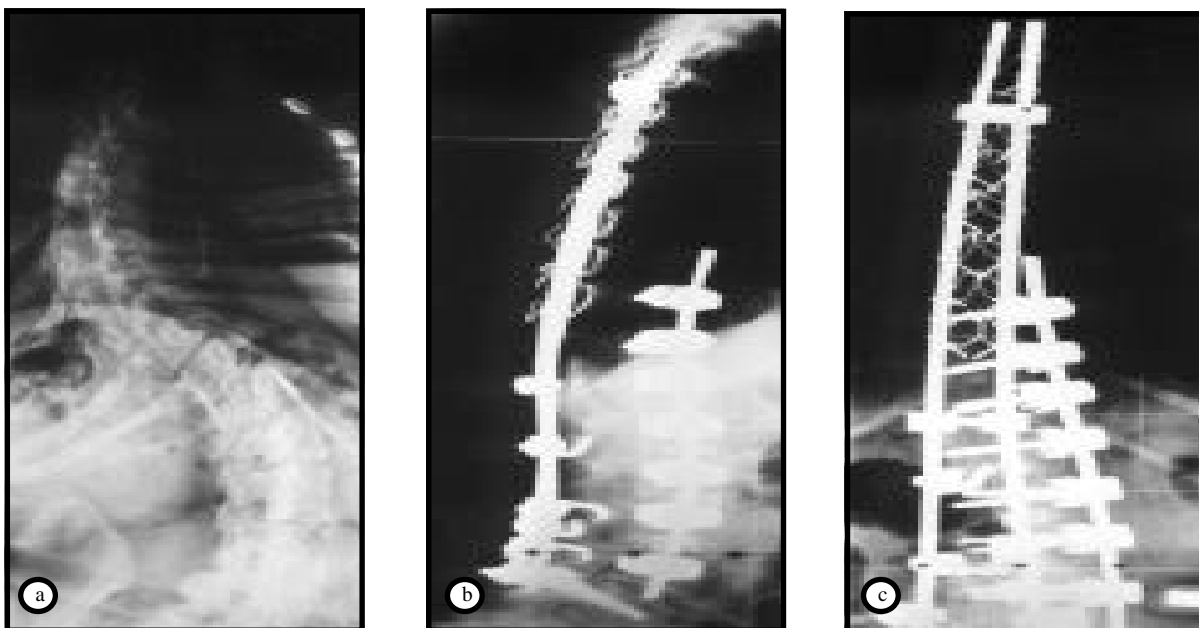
An anteroposterior radiograph showing the curves in spinal muscular atrophy a) after anterior release b) correction of curves with anterior and c) posterior instrumentation.
